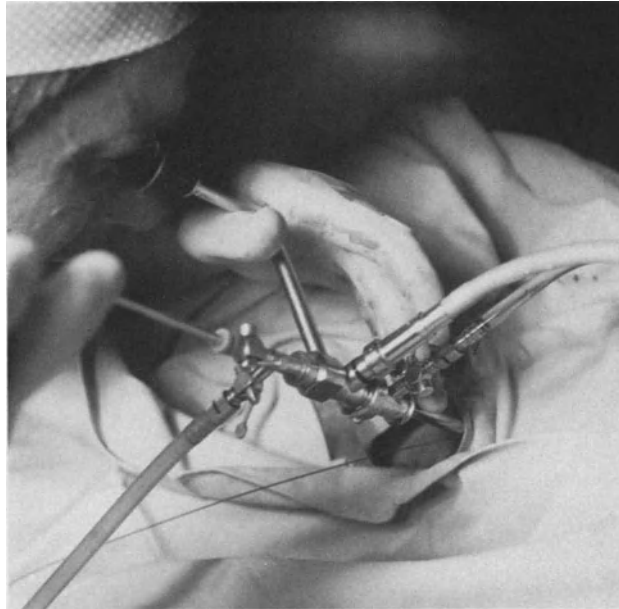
Nephroscopes with sonotrode for ultrasonic lithotripsy introduced through the working port (Storz, Wolf)
